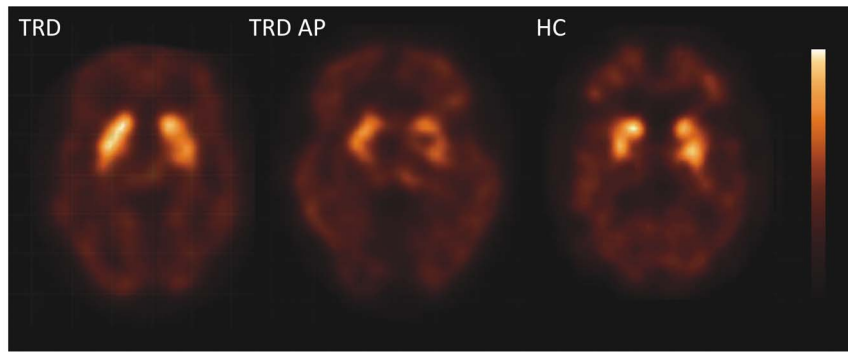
Transversal images of D2/3R availability. Transversal [¹²³I]IBZM SPECT slices at the level of the striatum showing D2/3 receptor availability in a TRD patient, a TRD patient on antipsychotics (TRD AP), and a healthy control subject.
